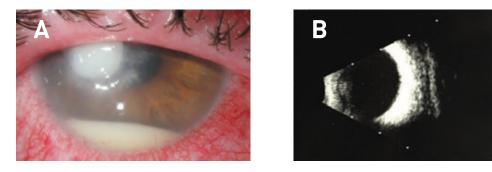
Clinical appearance on presentation to our Eve Clinic. (A) Large corneal epithelial defect and infiltrate, with endothelial plaque and hypopyon. (B) B-scan ultrasonography demonstrating absence of vitreal inflammation.
